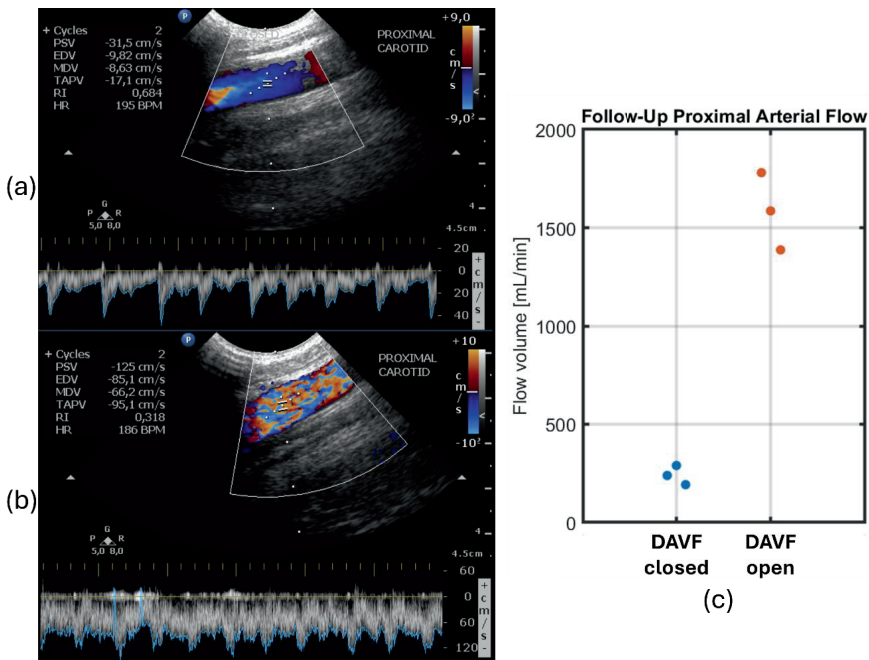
Blood flow measurements in the carotid artery as measured with Doppler Ultrasound 1 week after device placement. a) Ultrasound image of the proximal arterial flow ~5cm from the Arteriovenous Fistula (AVF) with the Dynamic AVF (DAVF) in closed position, and b) in open position. c) The estimated volumetric flow rates of the 3 measurements performed in both positions.
